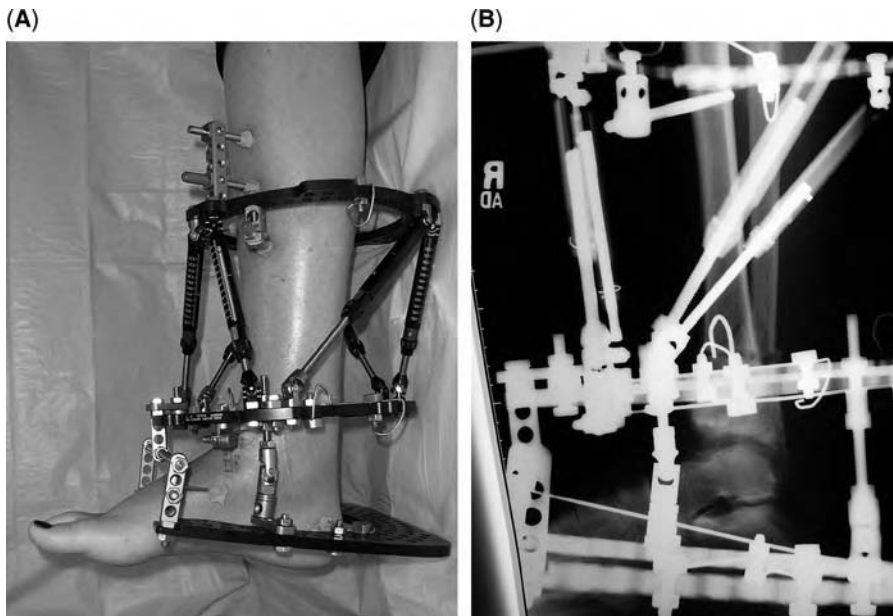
(A and B) Side view and X-ray of a patient who underwent a supramalleolar osteotomy for deformity correction and simultaneous ankle distraction.
